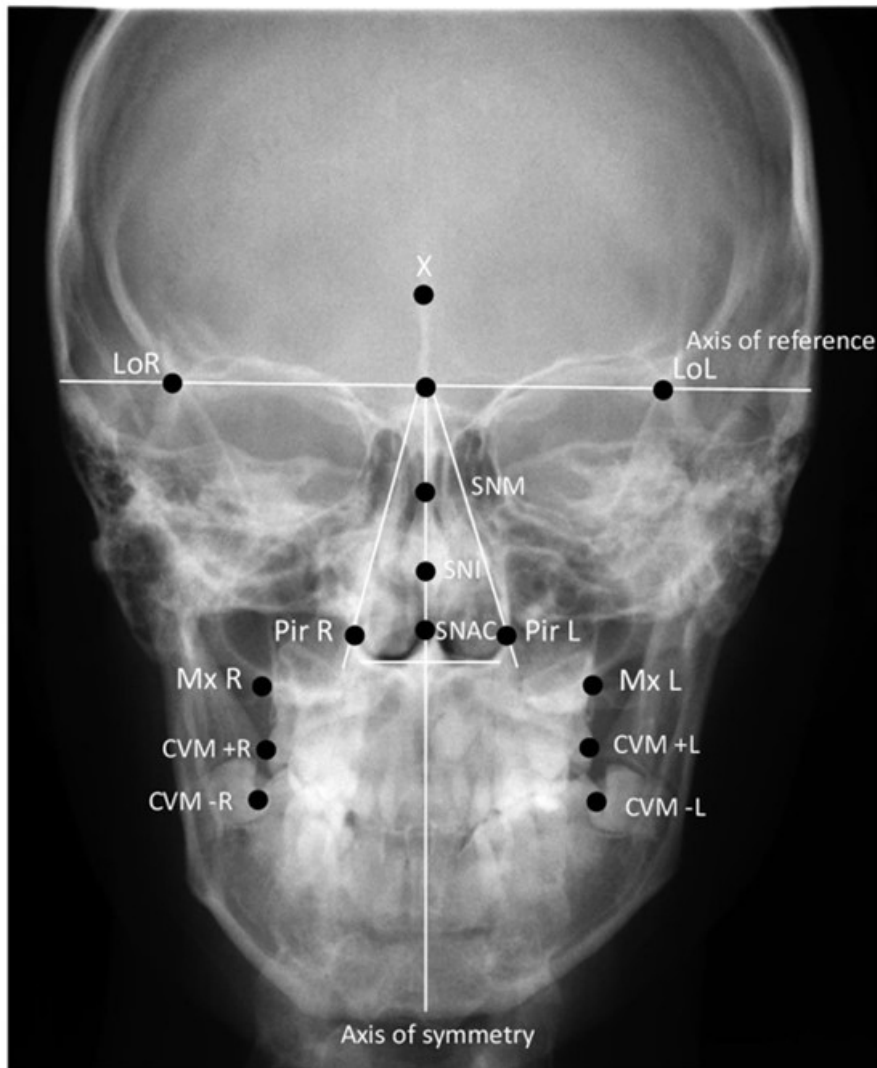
Reference points on PA cephalometric radiography. The reference points from which the measurements were made are presented on the PA cephalometric radiograph of the patient with nasal septum deviation.
